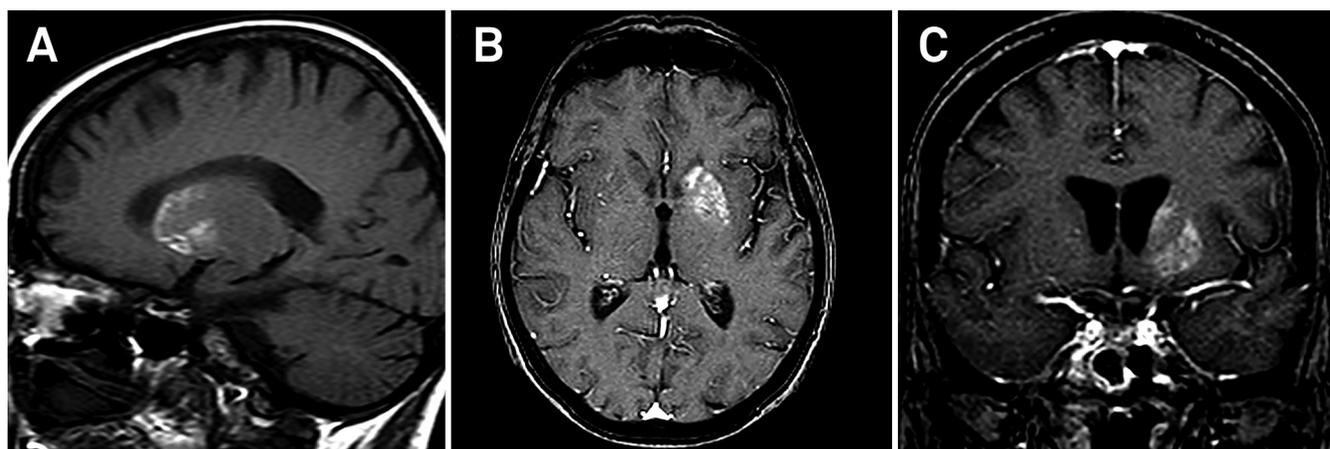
A) Sagittal T1-weighted magnetic resonance imaging showing spontaneous diffuse high intensity of the left striatum (caudate nucleus and putamen). B and C) There is no significant enhancement on axial and coronal T1-weighted MRI after intravenous paramagnetic contrast administration.
